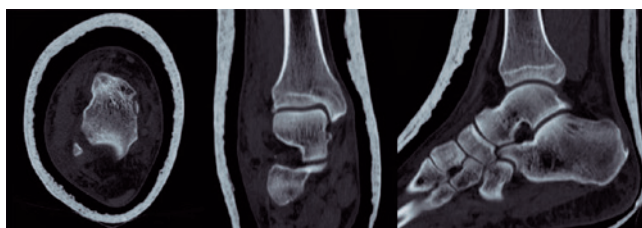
Computed tomography (axial to the left, sagittal in the center, and coronal to the right) post-reduction of pure talus dislocation, showing no associated fractures.
